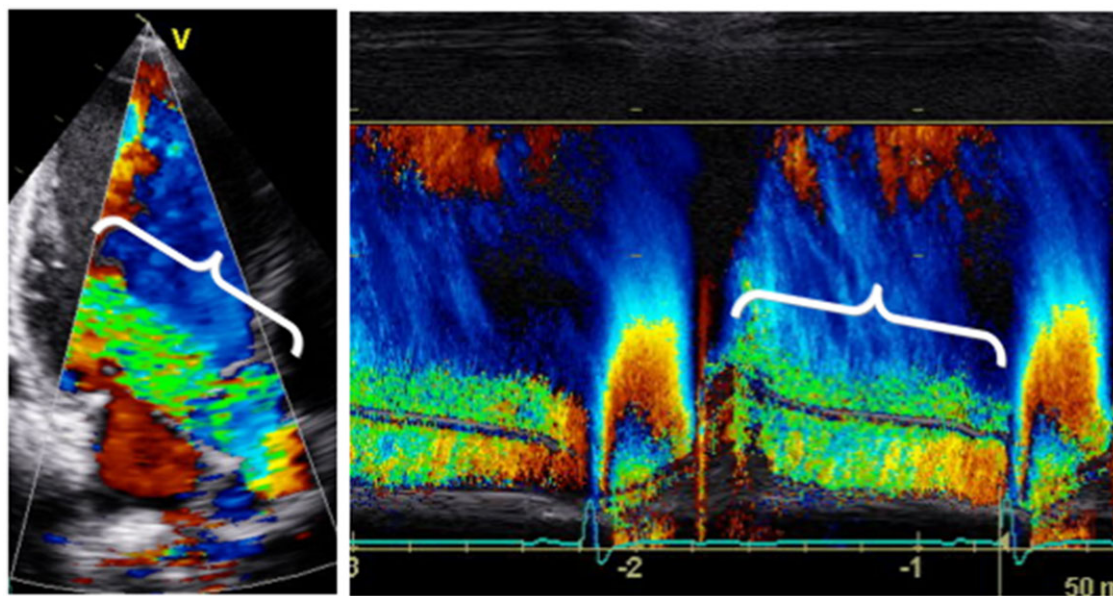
(A) Colour Doppler showing a severe AR. (B) Colour-coded M-mode depicting the time-dependency of flow signal during the heart cycle.
